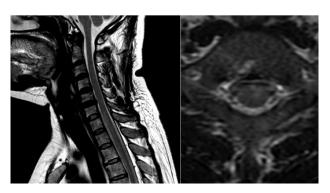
Sagittal STIR MRI showing ventral cord hyperintensity extending from C6 to D3.
